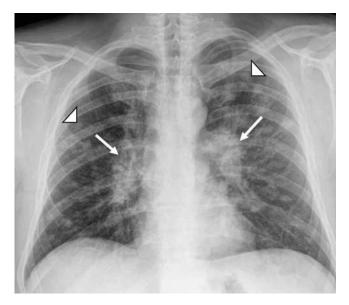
Postero-anterior radiograph of the thorax displays bilateral hilar adenopathies (arrows) with multiple nodular opacities bilaterally (arrowheads) with dominant predilection for the upper lobes.
